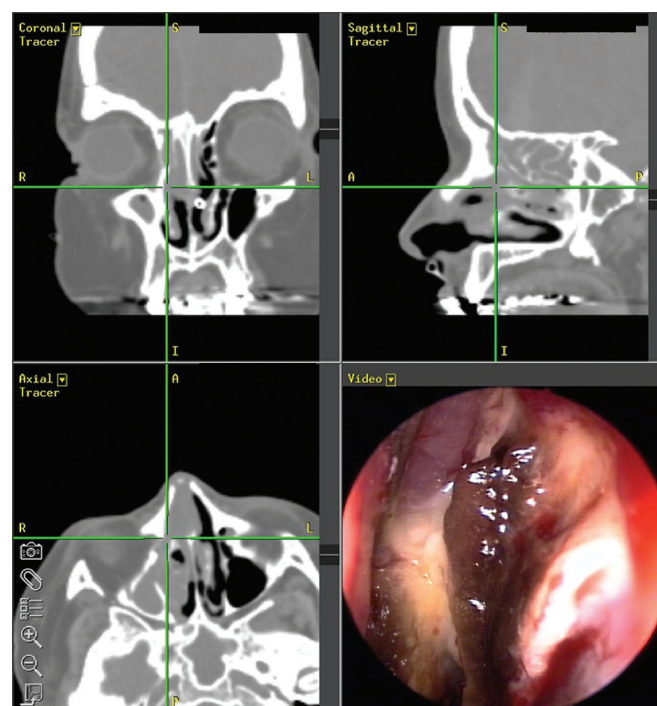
Acute invasive fungal rhinosinusitis as seen on nasal endoscopy and diagnostic imaging. The endoscopic view of the right nasal cavity reveals a middle turbinate with significant black mucosal discoloration, suggestive of tissue necrosis from thrombosis-induced ischemia. The coronal, axial, and sagittal views of the computed tomography scan from the patient demonstrate predominantly unilateral soft tissue thickening and opacification of the right nasal cavity, specifically the ethmoid and sphenoid sinuses.
